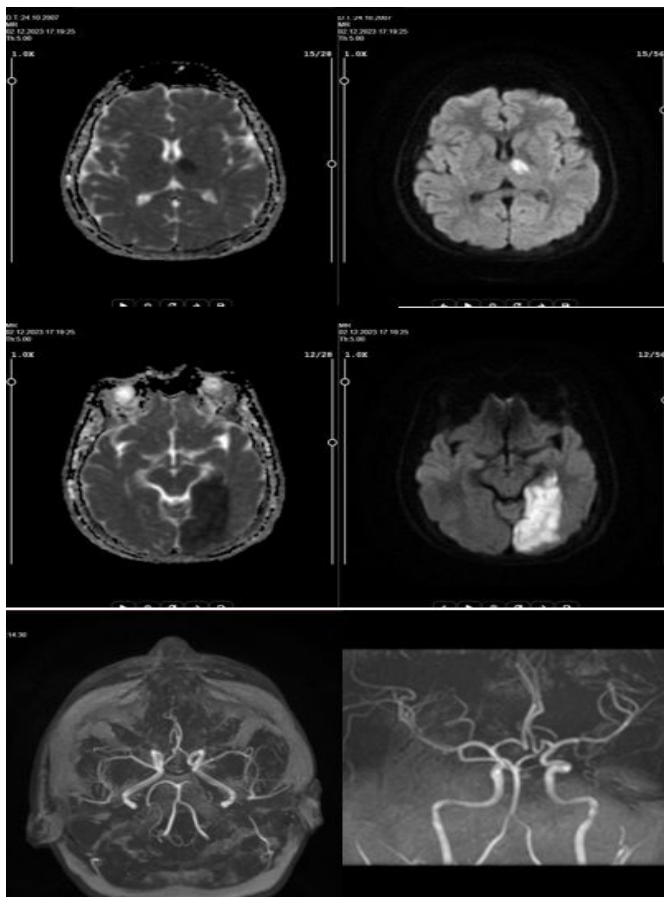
Diffusion MR images show that there was diffusion restriction in favor of acute ischemia in the anterior part of the left thalamus and the left PCA irrigation area. Brain MR-angiography images showed that there was no filling in the patient’s left posterior cerebral artery after the P1 segment
